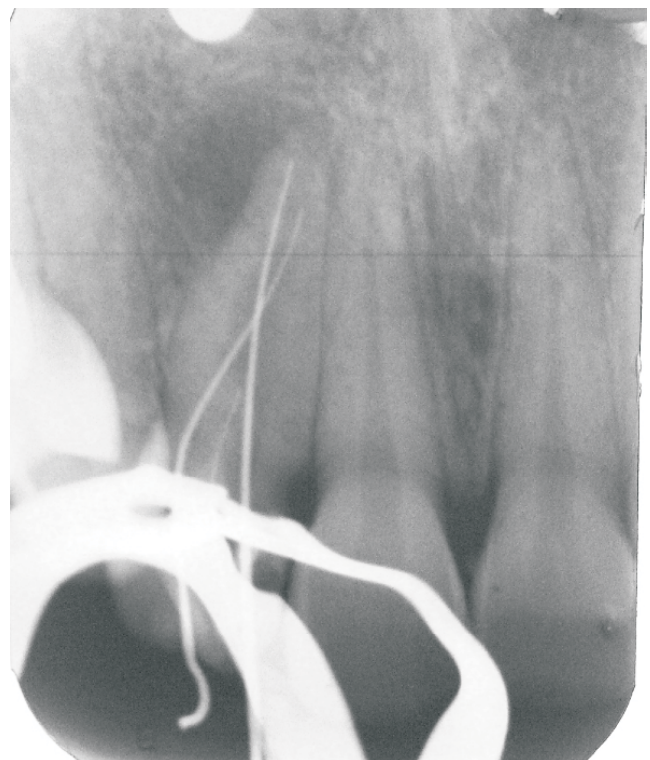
Working length radiograph.
